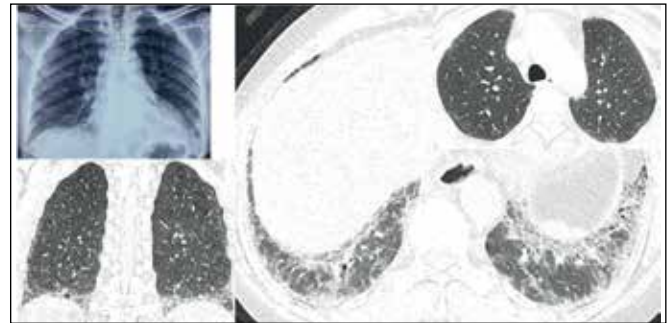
A 45-year-old female systemic sclerosis patient. Chest radiograph (postero-anterior view) showing mild bilateral basal reticulations. HRCT (axial and coronal reformatted images) showing GGO with inter- and intra-lobular reticulations in the posterior and basal regions of the bilateral lower lobes with bronchiolectasis, suggestive of NSIP.
